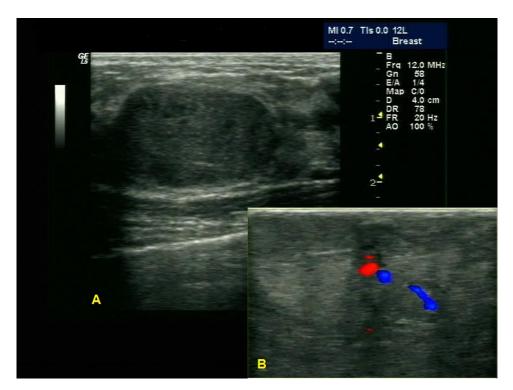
(A) Ultrasonography shows solid masses in the left breast with a sharp demarcation from the background breast tissue and relatively uniform echoes. (B) Color Flow Imaging shows that short strip-shaped color flow signals are visible in the breast masses.
